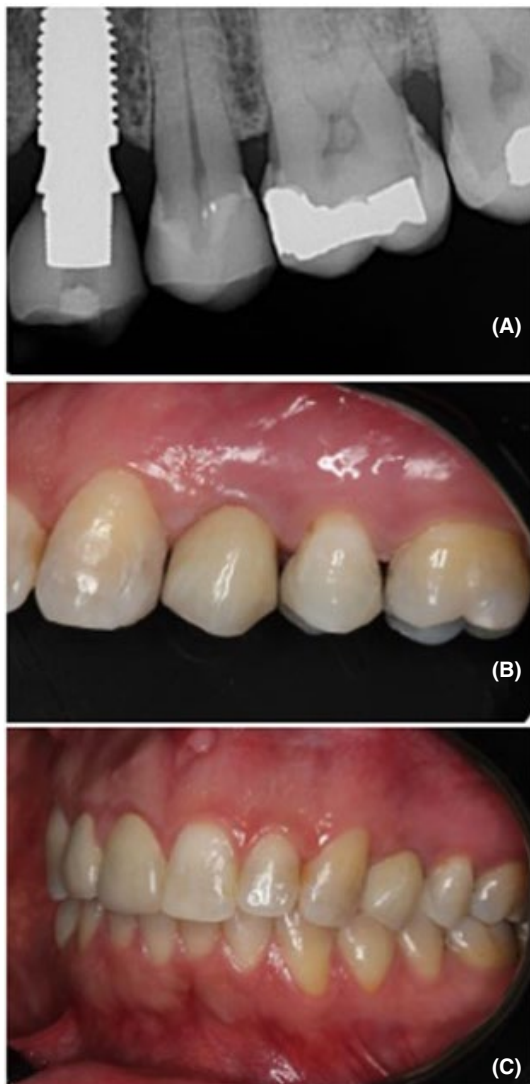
(A–D) Clinical and radiographic aspects of patient 2's rehabilitation at the 12-month follow-up visit
